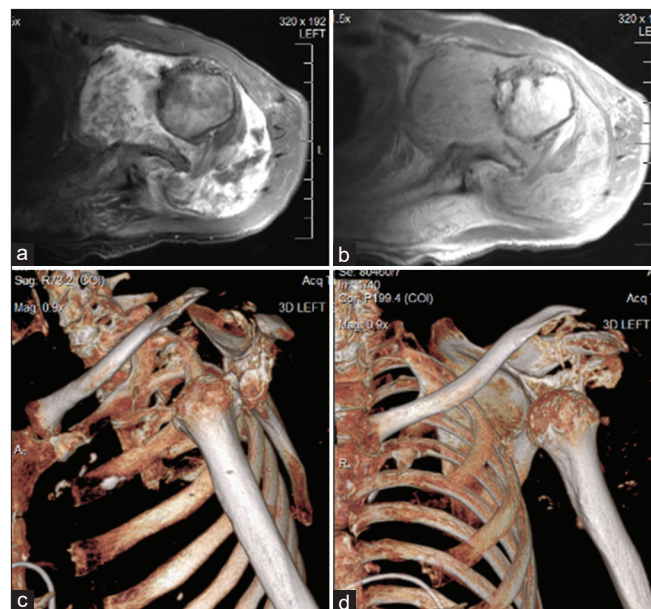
MRI scan left shoulder: (a) Axial T2. (b) Axial T1. (c) Transthoracic reconstruction. (d) AP reconstruction
